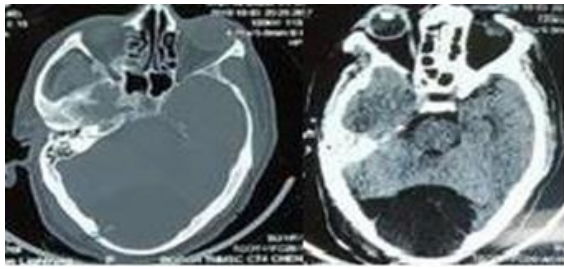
CT brain plain shows midline posterior fossa arachnoid cyst with thin septations and scalloping of the occipital bone
